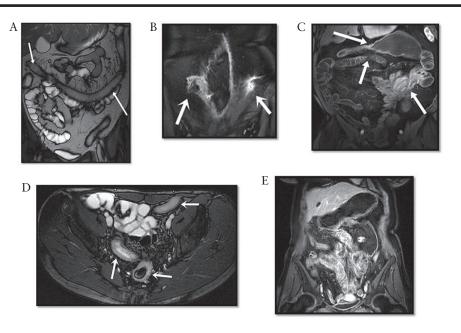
Representative small bowel MRI sequences. [A] TRUFI-sequence small bowel MRI; Crohn's disease with inflammatory colon transversum. [B] T2 weighted small bowel MRI; penetrating Crohn's disease presenting enterocutaneus fistulas. [C] Contrast-enhanced T1-weighted small bowel MRI; Crohn's disease indicating severe inflammation including stenosis and prestenotic dilatation. [D] TRUFI-sequence small bowel MRI; Crohn's disease with segmental inflammation of the jejunum, terminal ileum, and anorectum. [E] Contrast-enhanced T1-weighted small bowel MRI. Sequence with poor image quality due to breathing artefacts and intestine peristalsis.
